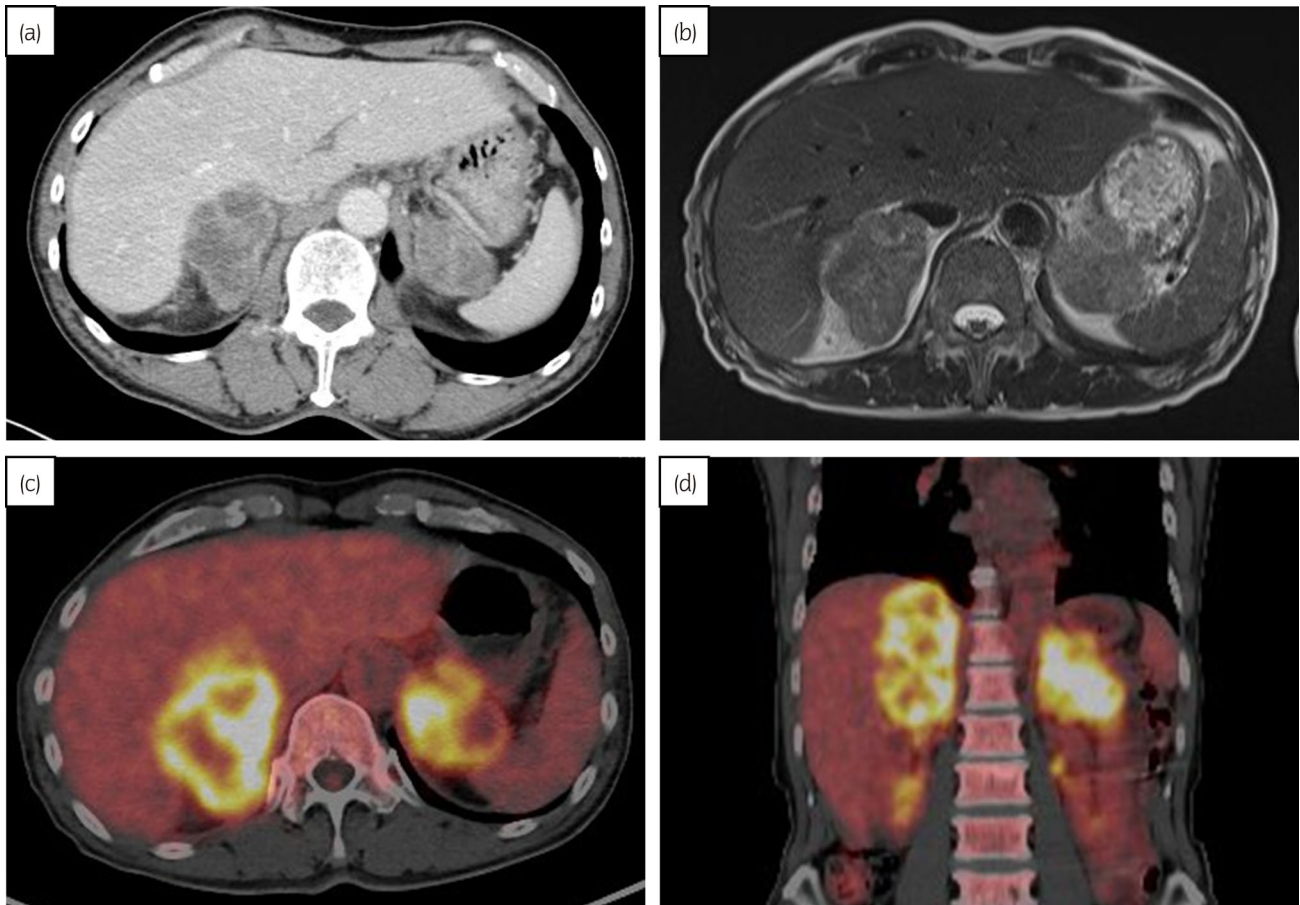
CT, magnetic resonance imaging, and FDG-PET CT findings of bilateral adrenal tumors. (a) Axial section of contrast-enhanced CT, (b) axial section of T2-weighted magnetic resonance imaging, (c) axial section of FDG-PET CT, and (d) coronal section of FDG-PET CT.
